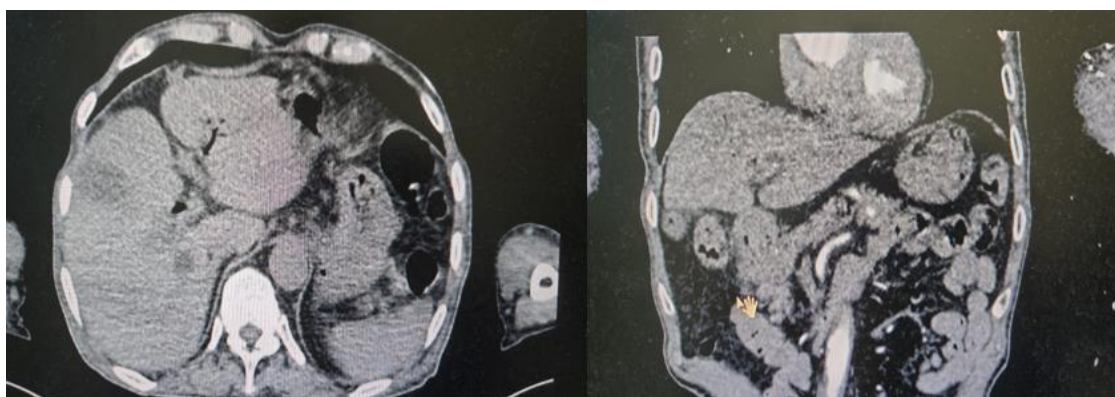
CT angiography demonstrating marked aerobilia and the bulbo-biliary fistulous tract.
